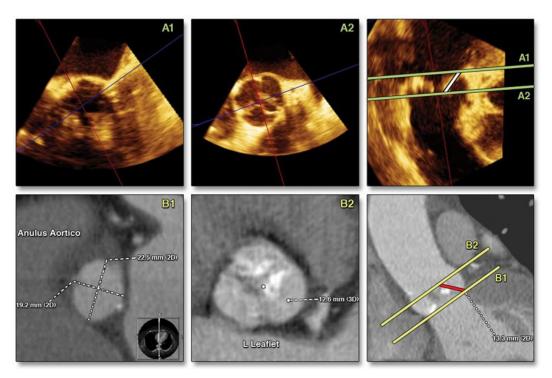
LCC Length Measured by 3DTEE and MDCT. (Top) Example of 3DTEE measurement of the left coronary cusp (LCC) length. A short-axis view (A1) at the level of AA (top, left); a shortaxis view (A2) at the level of the tip of the leaflets (top, middle); a sagittal view of the ascending aorta with the LCC length (white line) measured as the distance between plane A1 and A2 (top, right). (Bottom) Example of multidetector computed tomography (MDCT) measurement of the LCC length. A short-axis view (B1) at the level of AA (bottom, left); a short-axis view (B2) at the level of the tip of the leaflets (bottom, middle); a sagittal view of the ascending aorta, with the LCC length (red line) measured as the distance between plane B1 and B2 (bottom, right). Abbreviations as in Figure 1.
